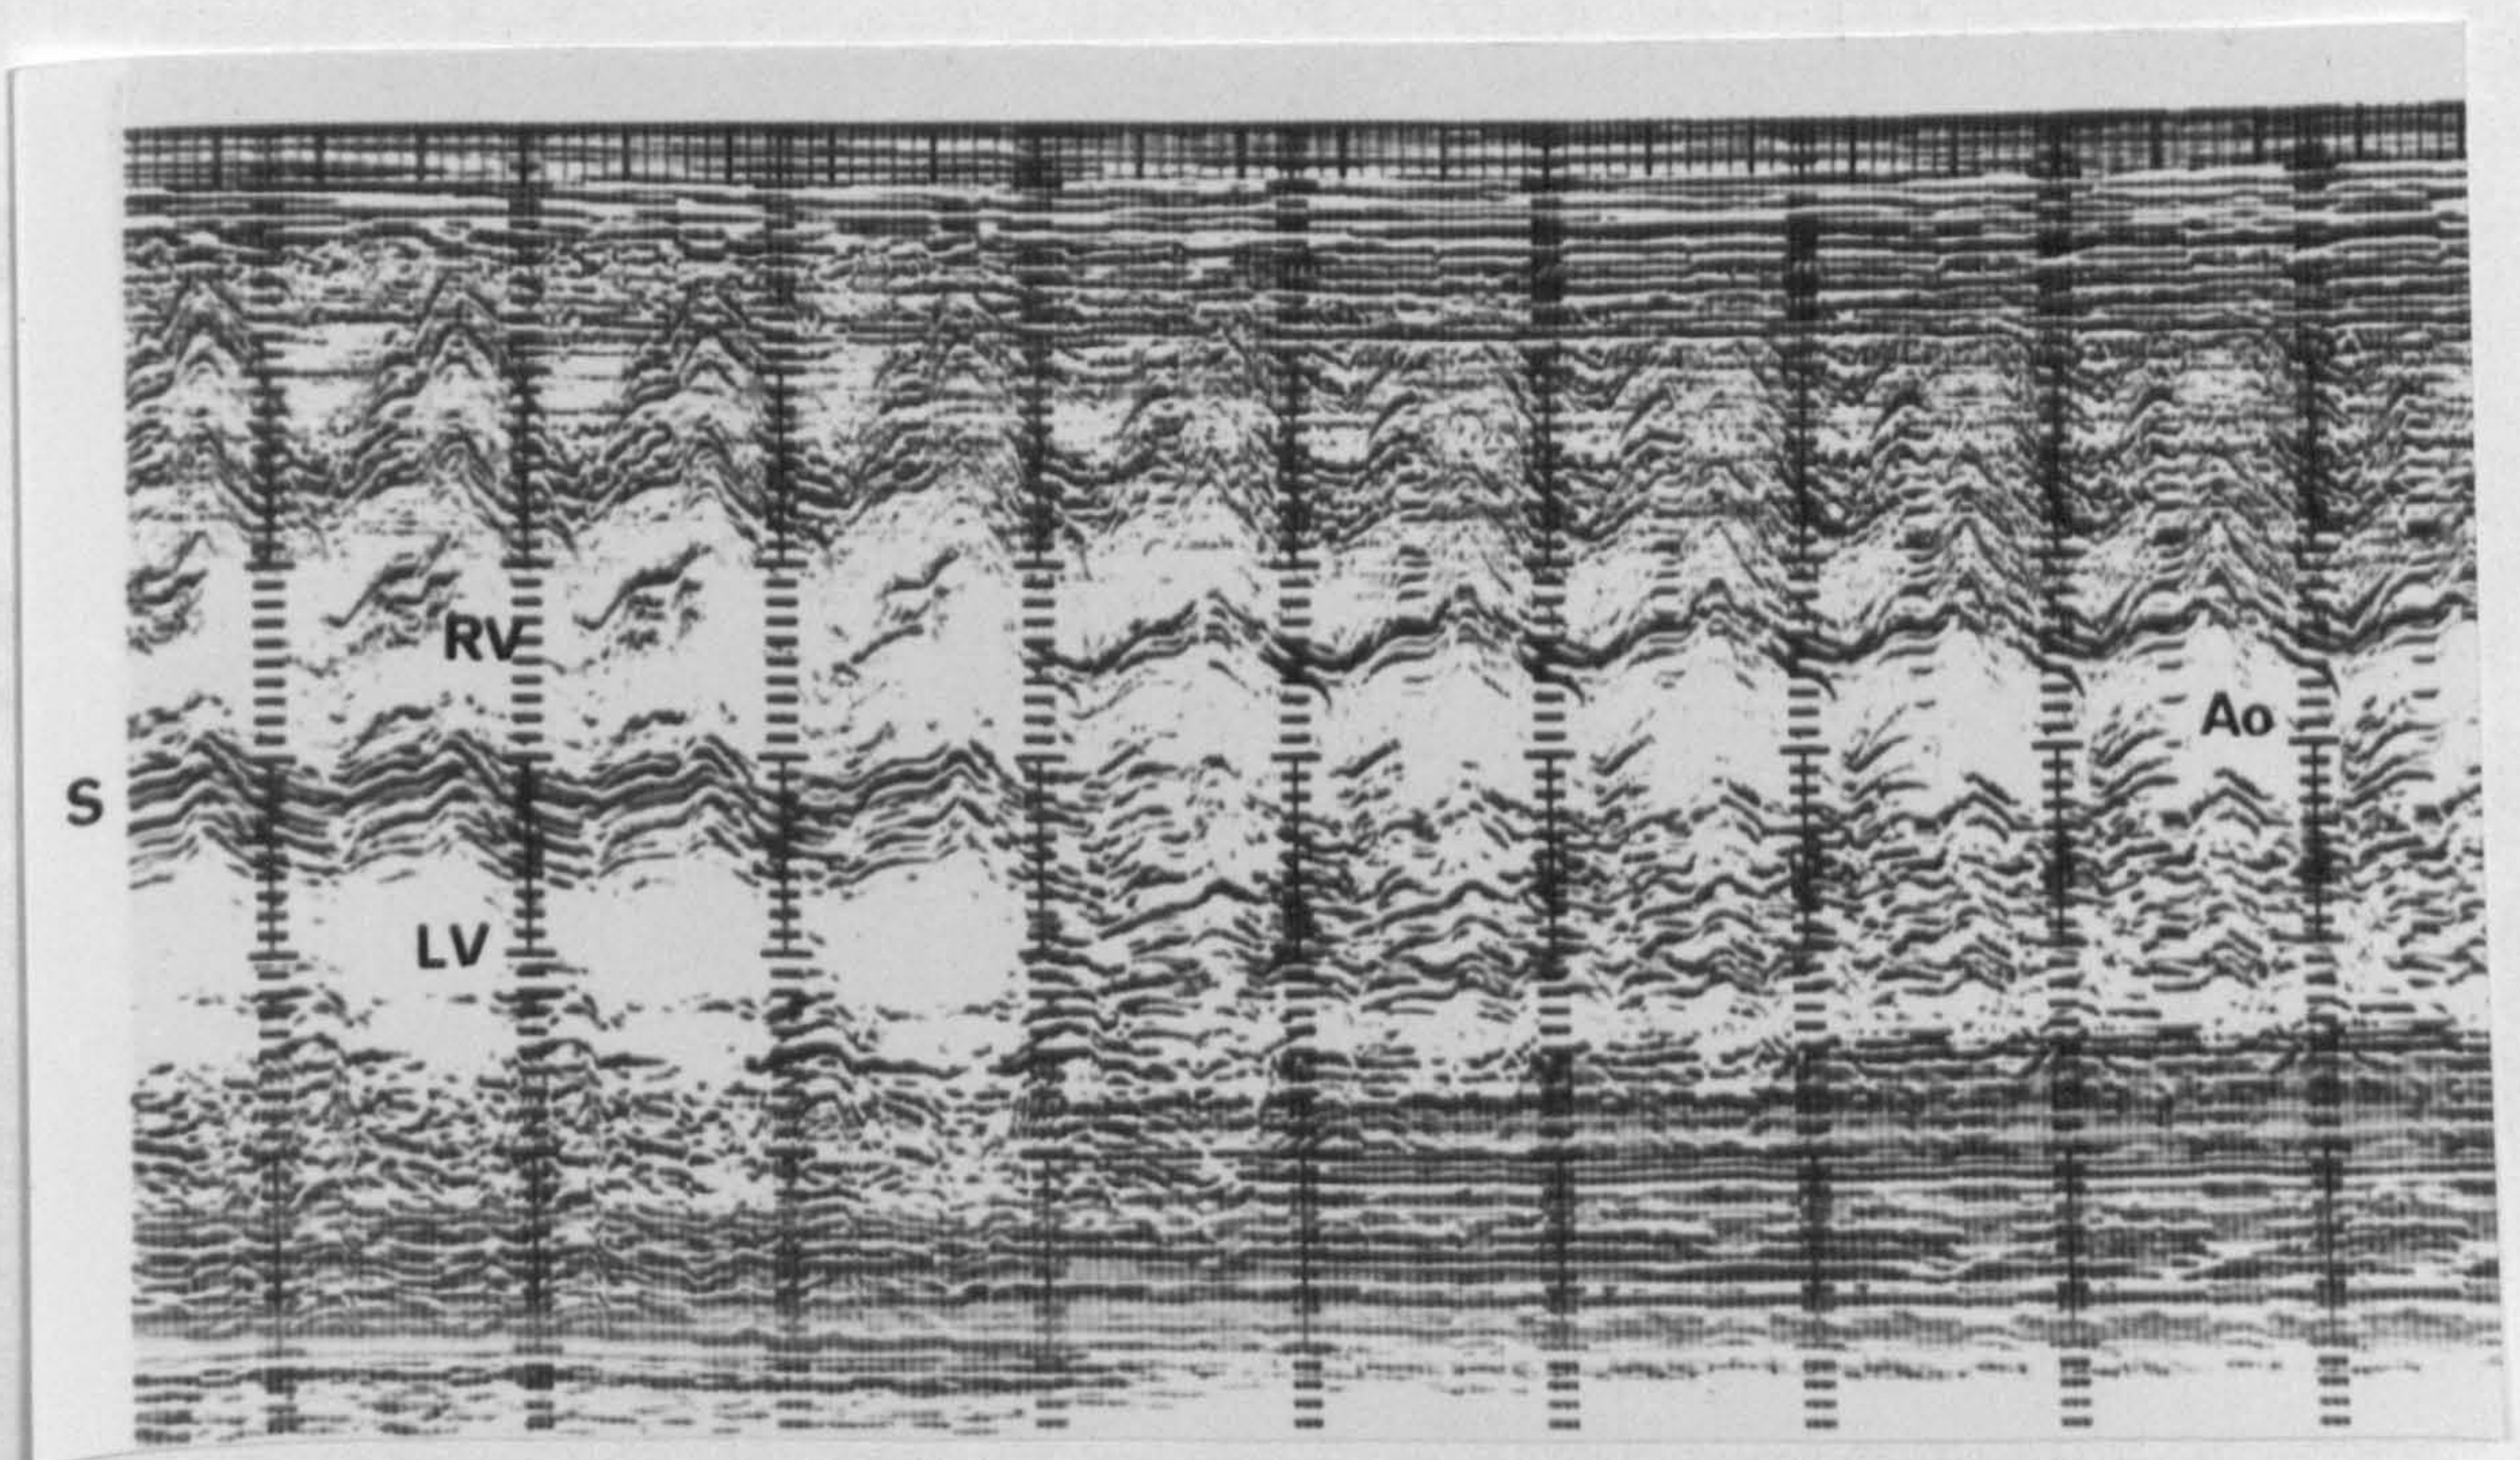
Case 4. The prenatal M mode echocardiogram. The aorta appears to arise mainly from the right ventricle.
